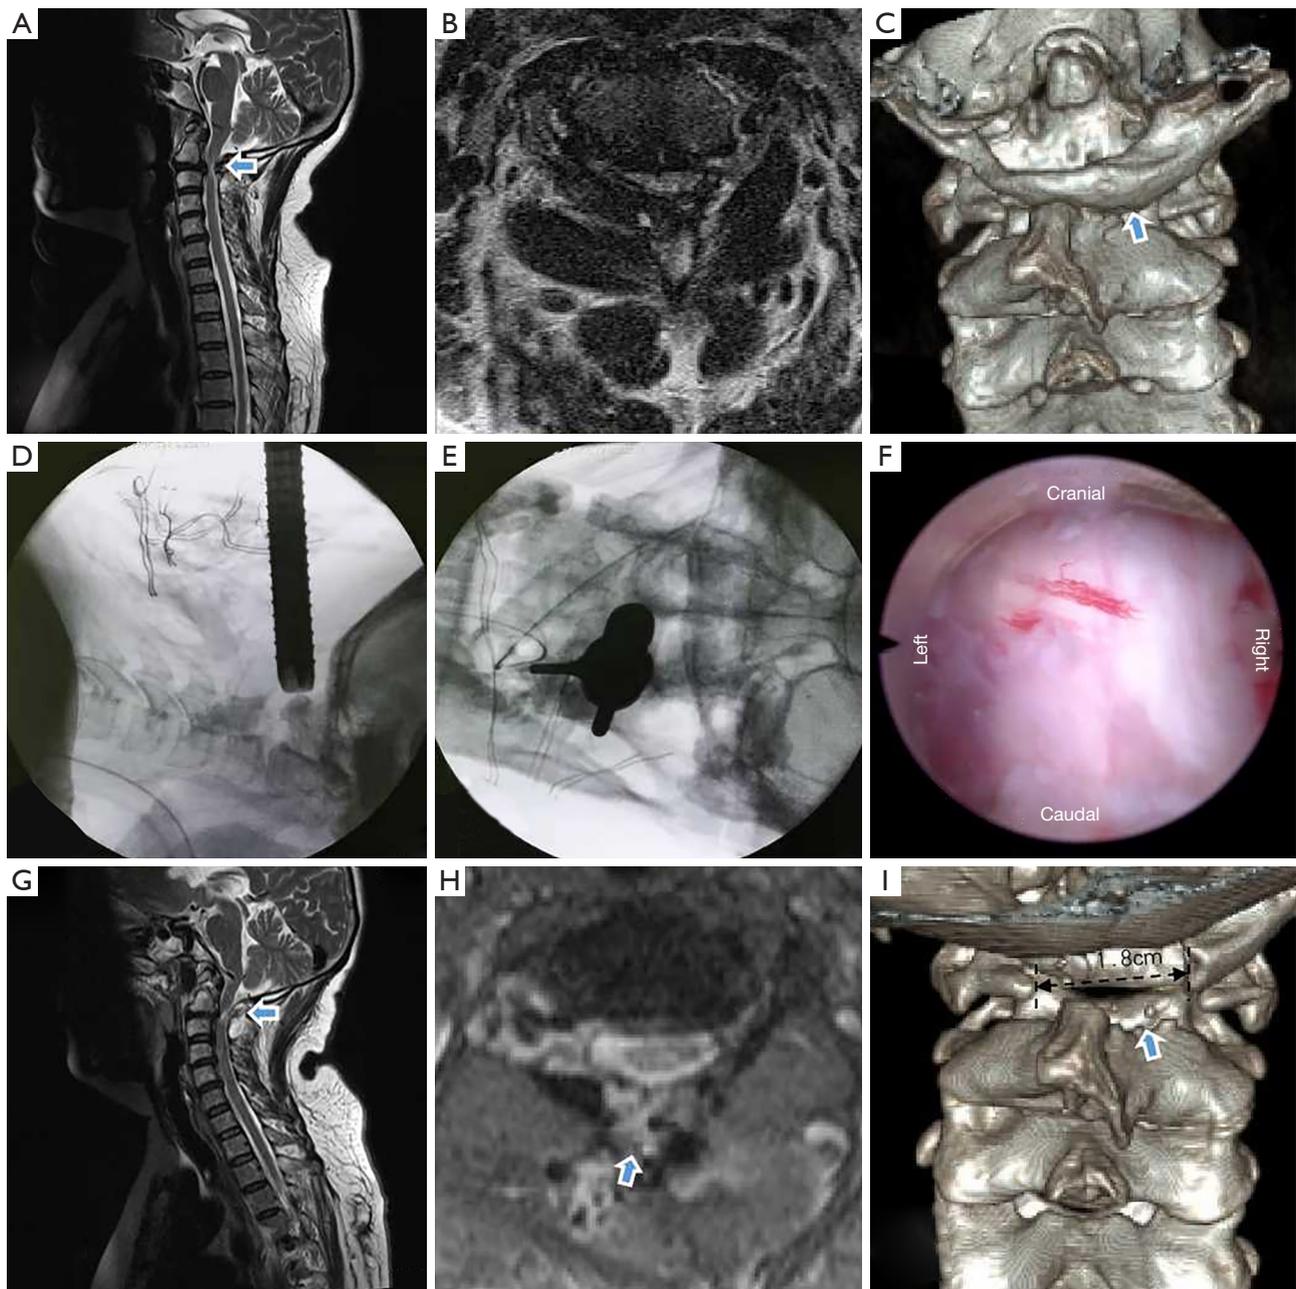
A 52-year-old female with DASM who accepted PFEC1L and percutaneous full endoscopic partial hemilaminectomy at the upper half of C2. (A) Preoperative mid-sagittal MRI. The arrow indicated the compression of the spinal cord at the level of C1–2. (B) Preoperative axial MRI showing deformity of PAA as a cause of spinal cord compression. (C) Preoperative CT scan. The arrow indicated the developmental malformation of the PAA. (D,E) Intraoperative fluoroscopy to confirm the location of the working channel. (F) Full spinal cord decompression can be observed at endoscopy. (G,H) Postoperative MRI. The arrow indicated that the atlas canal was enlarged and the spinal cord compression was relieved. (I) Postoperative CT three-dimensional reconstruction. The arrow indicated that the PAA and the right C2 part of lamina was removed and the resection of the PAA was about 1.8-cm. DASM, developmental atlantal stenosis with myelopathy; PFEC1L, percutaneous full endoscopic C1 laminectomy; MRI, magnetic resonance imaging; PAA, posterior arch of the atlas; CT, computed tomography.
